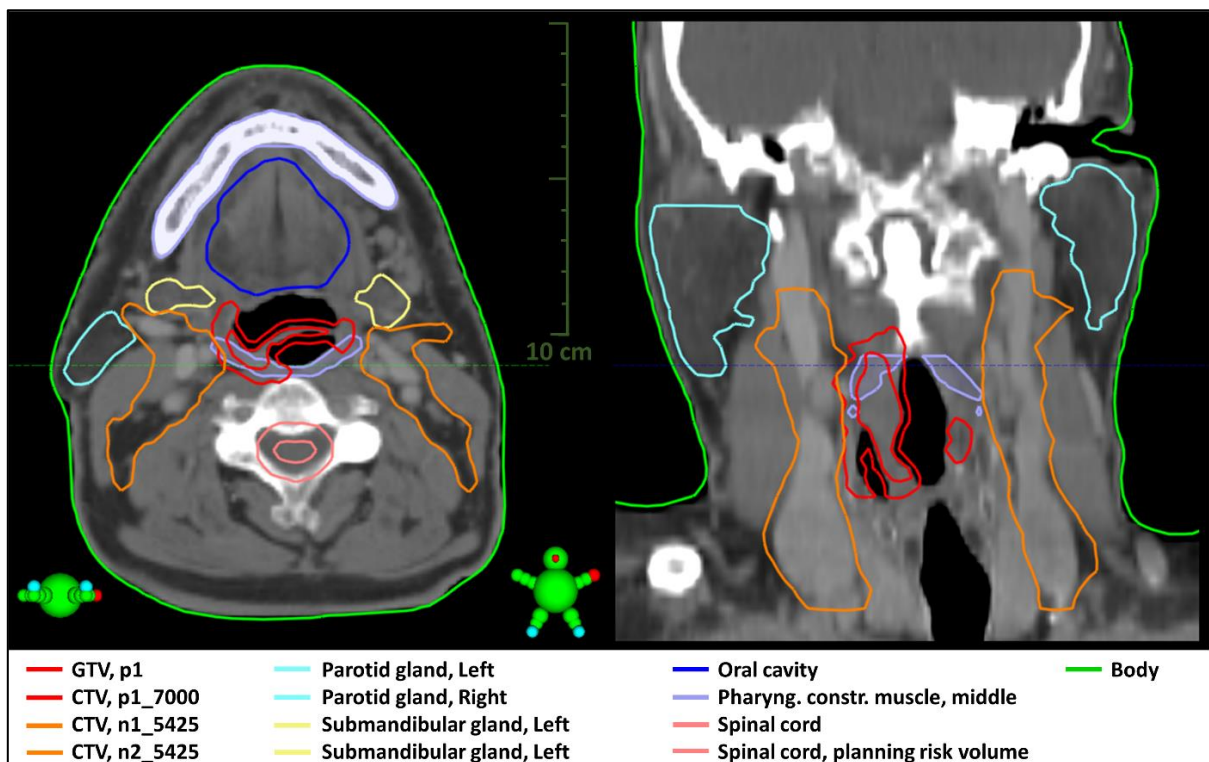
Visualization of an axial (left) and a coronal (right) slice of the planning CT for a patient with a locally advanced tumor of the supraglottic larynx. The GTV and the associated high-risk CTV are delineated in red. The low-risk CTV, consisting of the elective lymph nodes, is delineated in orange. A number of important organs-at-risk are delineated as well: the parotid glands, submandibular glands, oral cavity, middle pharyngeal constrictor muscle and the spinal cord.
